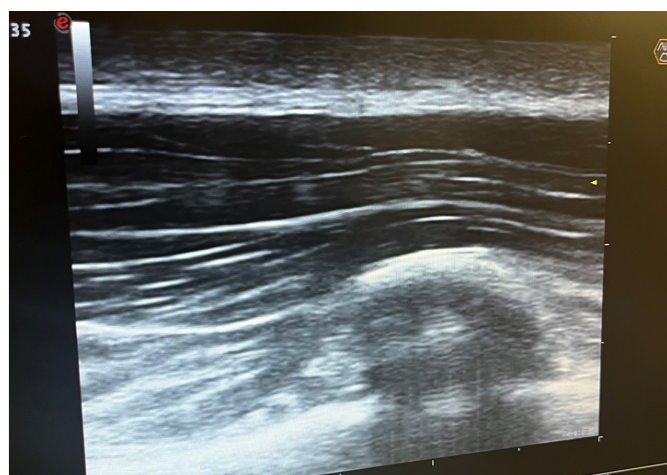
Ultrasound image of the serratus posterior superior intercostal plane (SPSIP) block—needle trajectory and target plane
